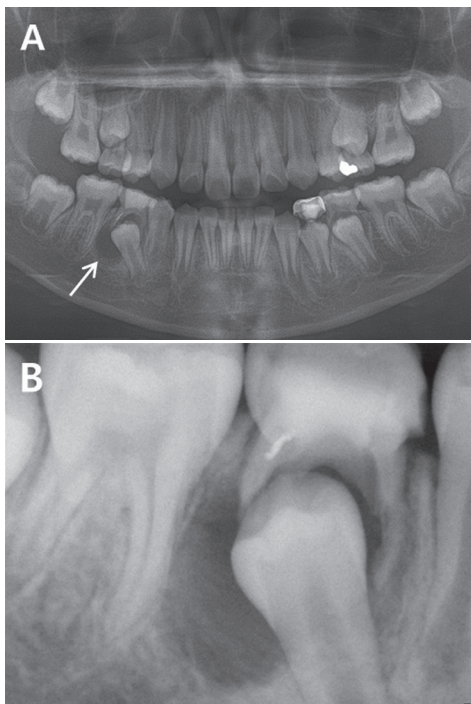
Panoramic and periapical radiographs (A, B) show a well-defined radiolucent lesion (white arrow) associated with the treated deciduous molar and second premolar with an ectopic eruption path. Osteosclerotic change around the cyst wall due to the chronic inflammation state is shown.
